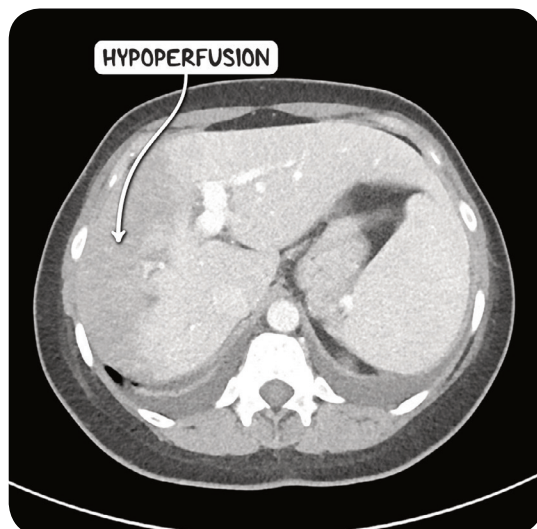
An abdominal CT scan in the axial plane demonstrating hypoperfusion of the right lobe of the liver secondary to Budd-Chiari syndrome.
